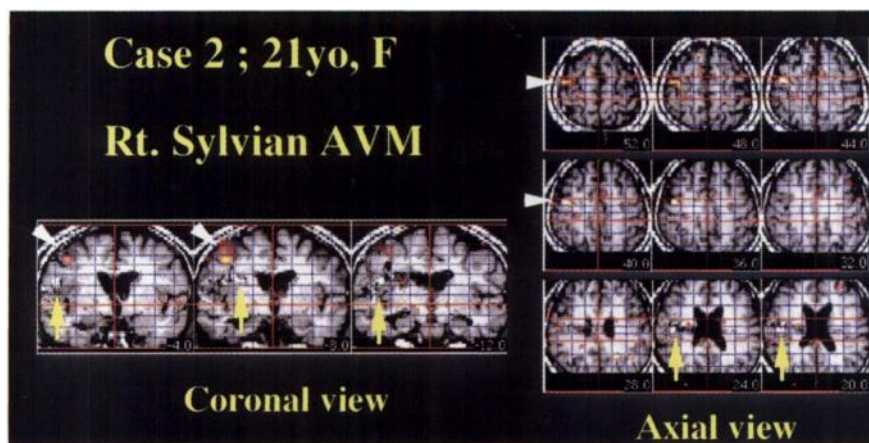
Subtracted PET images of Patient 2 superimposed on the MR images in the axial and coronal sections. Coregistration of PET and MRI clearly visualized the activated primary motor area (arrow heads) and its adjacent relationship to the AVM. High signal intensities in the nidus are posthemorrhagic change (arrows). The number at each slice level is the distance (millimeters) from the anterior commissure (AC) -posterior commissure (PC) plane in the axial view and the distance from the AC in the coronal view.
